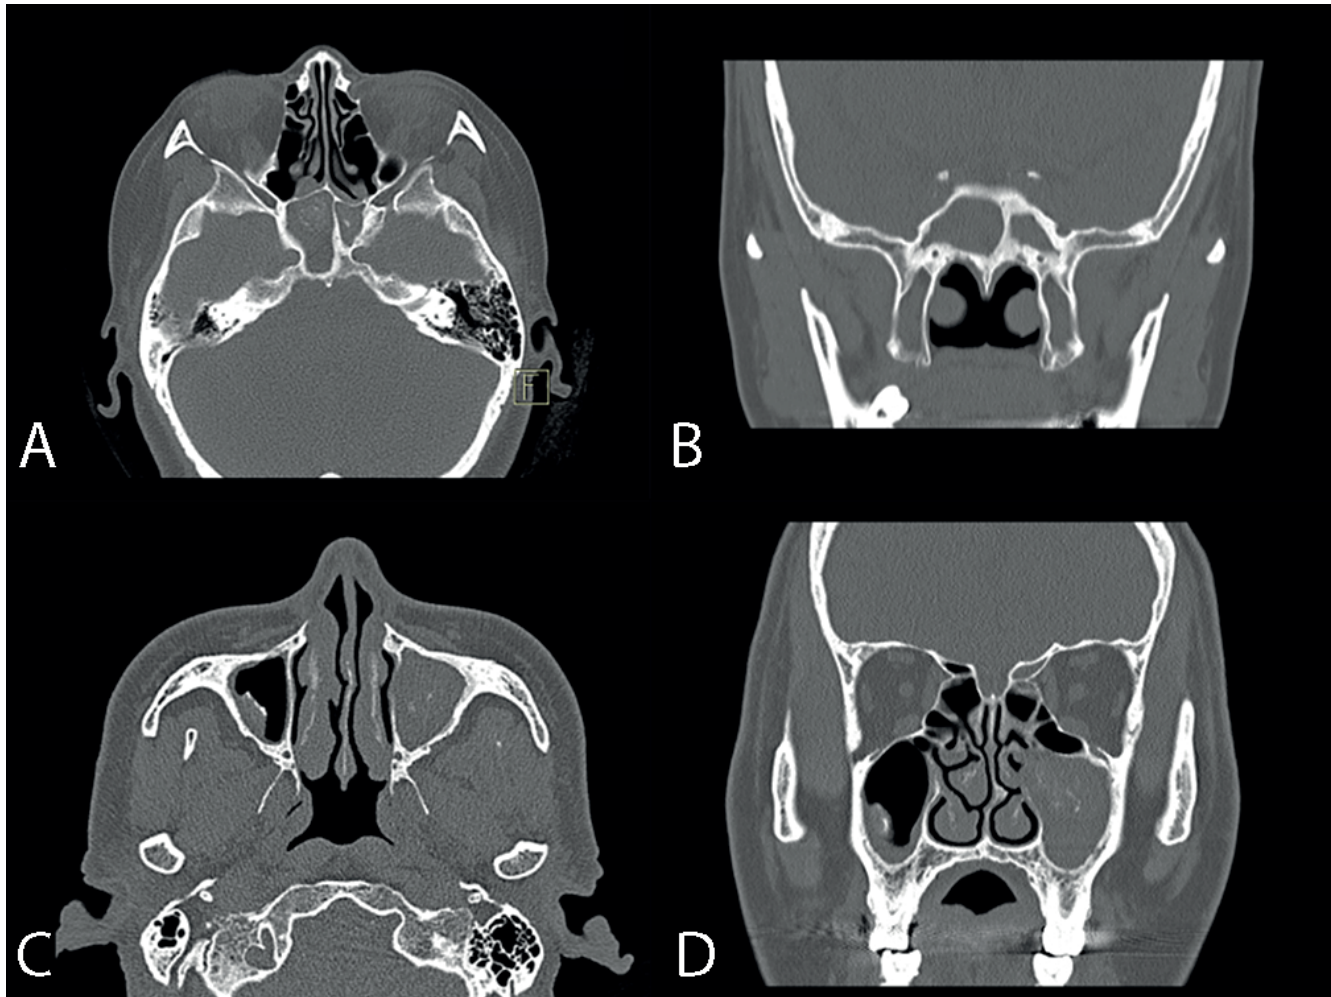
CT images of bilateral maxillary and sphenoid sinus FB. (A) axial scan and (B) coronal scan of sphenoid sinus FB; (C) axial scan and (D) coronal scan of maxillary sinus FB.
